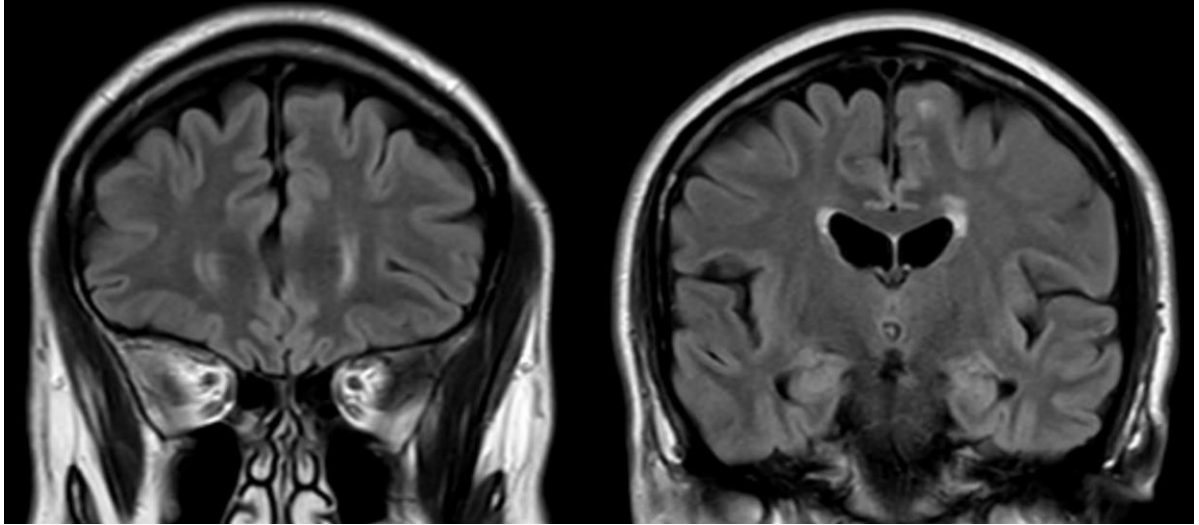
2. Example MRI slices of NB from 2015 showing the frontal lobe (Left) and temporal lobes (Right)
